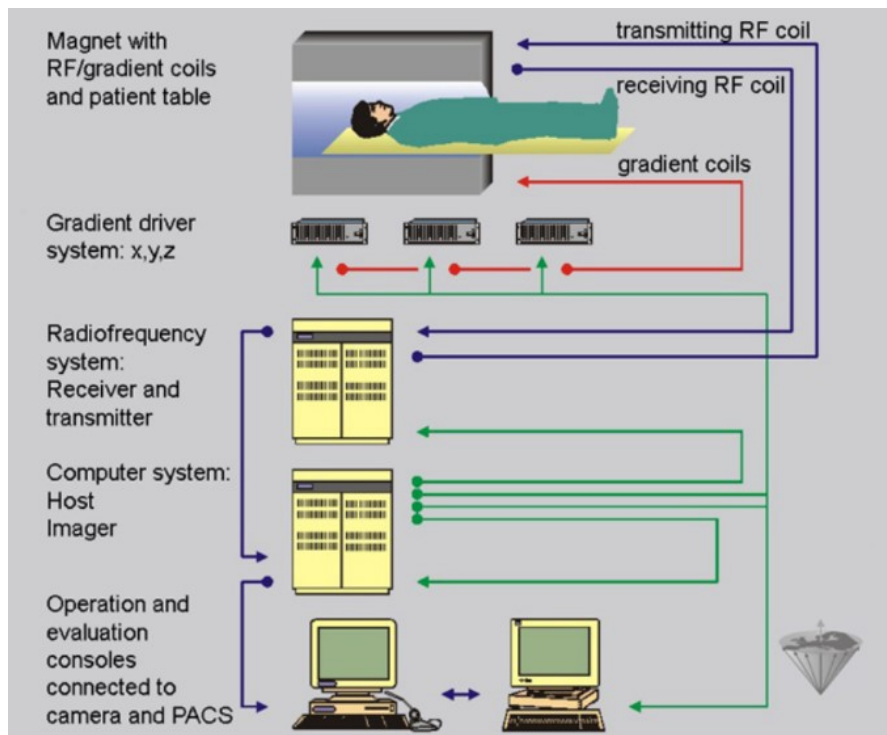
MRI scanner components and working principle [24]
